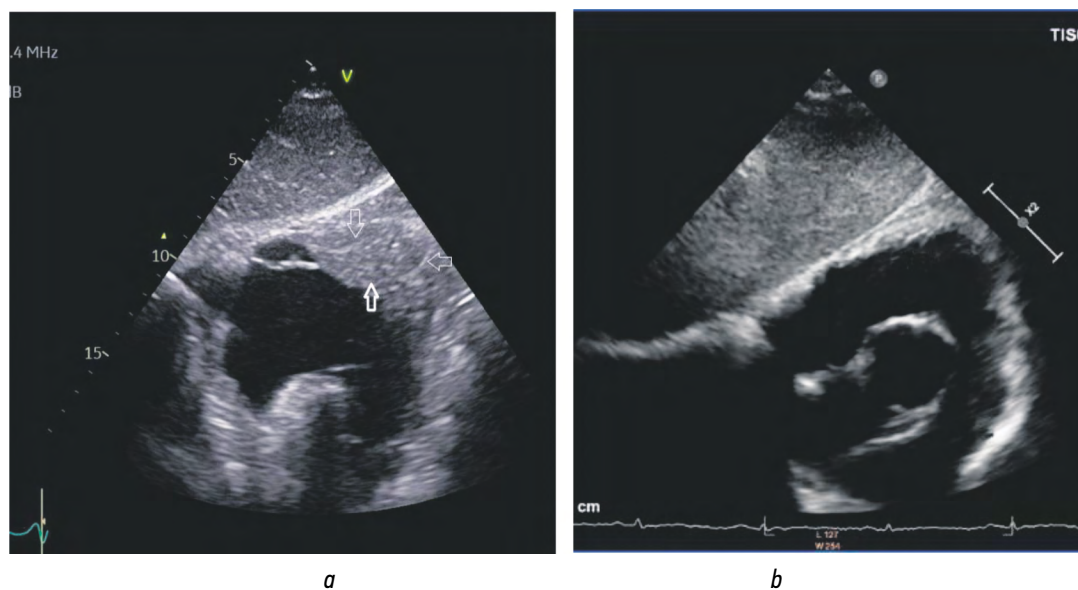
Echocardiographic changes in the right ventricular outflow tract: *a* — short-axis view at the level of the aortic valve, subcostal approach, reveals parietal masses located in the outflow tract of the right ventricle, indicated by the lower arrow. The arrows above and to the right delineate the myocardium of the right ventricle and a clear boundary between the myocardium and the parietal deposits. For comparison; panel *b* — displays the same section from a healthy individual, demonstrating a non-thickened right ventricular myocardium and absence of pathological parietal masses
